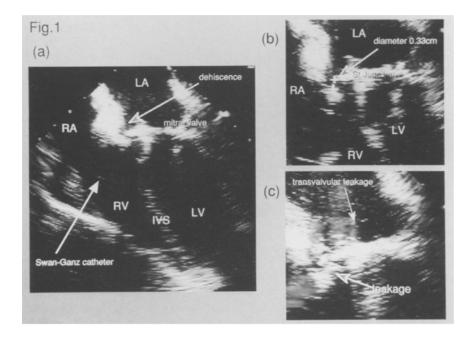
(a) Transesophageal echocardiography (TEE) four-chamber view obtained in the horizontal plane when cardiopulmonary bypass was terminated after mitral valve replacement. This view was obtained by retroflexion of the endoscope tip about 32 cm from the incisors. The dehiscence was seen at the points indicated by arrows. (b) The diameter of dehiscence was 0.33 cm. (c) TEE color-flow imaging of mitral regurgitation at systole. Perivalvular leakage (PVR) was seen at the points indicated by arrows. Transvalvular leakage, which is normal, was also observed. The jet area of PVR was 2.5 cm². RA, right atrium; RV, right ventricle; LA, left atrium; LV, left ventricle; IVS, interventricular septum
